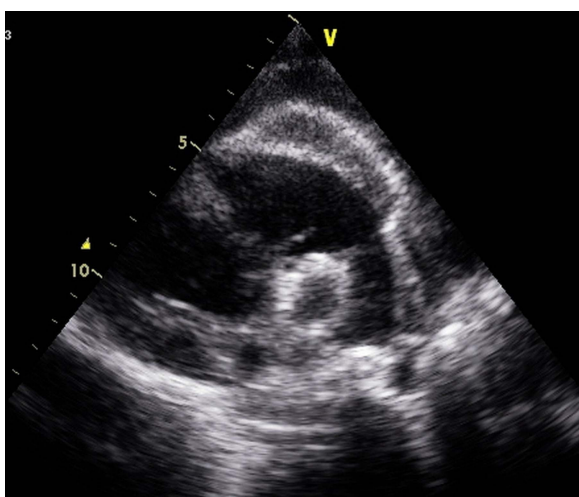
Echocardiography of a patient with right endomyocardial fibrosis found during a community study, showing obliteration of the ventricular cavity and ventricular cavity reduction.
